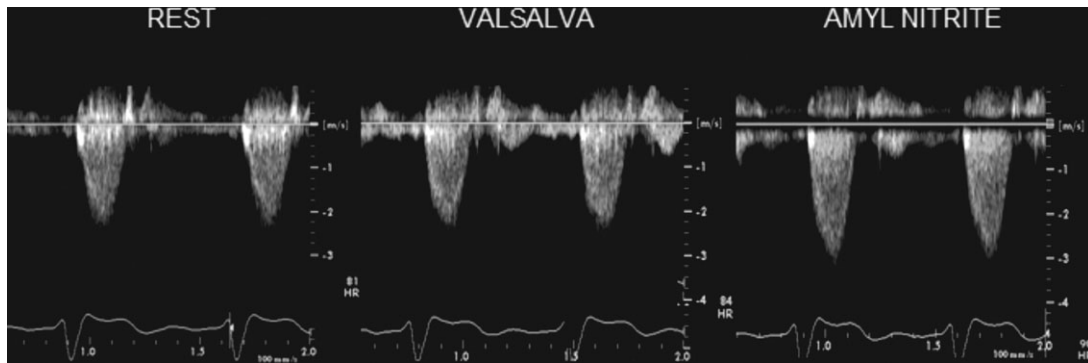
Continuous wave Doppler tracing of the LVOT shows the peak pressure gradient at rest (29 mm Hg), during the Valsalva manoeuvre (31 mm Hg), and with amyl nitrite (49 mm Hg) with an uniform systolic Doppler spectral profile.
